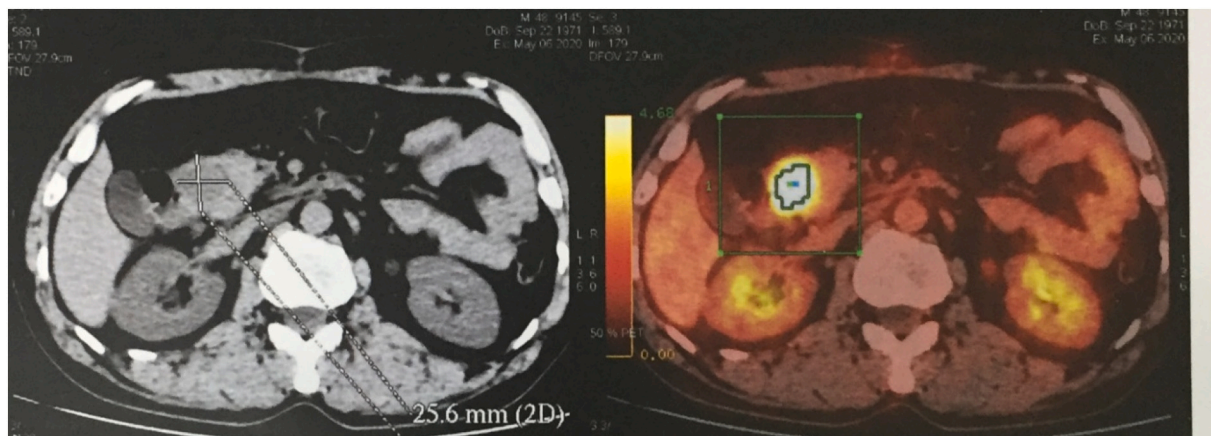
Macroscopic PET – CT findings. a low-density high- metabolism (SUV 15.0) mass measuring 26 × 28 mm in size in the parenchymal of pancreatic head.
